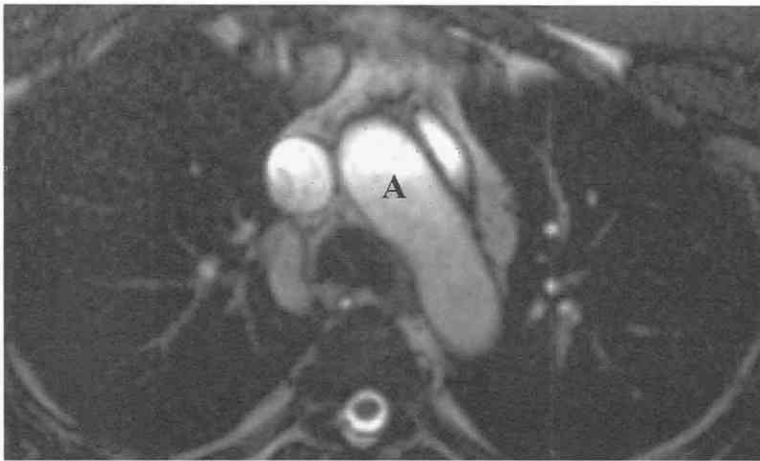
Axial cine gradient-recalled echo (GRE) MR image of the aortic arch shows the normal appearance of the transverse aorta. A = aorta.
